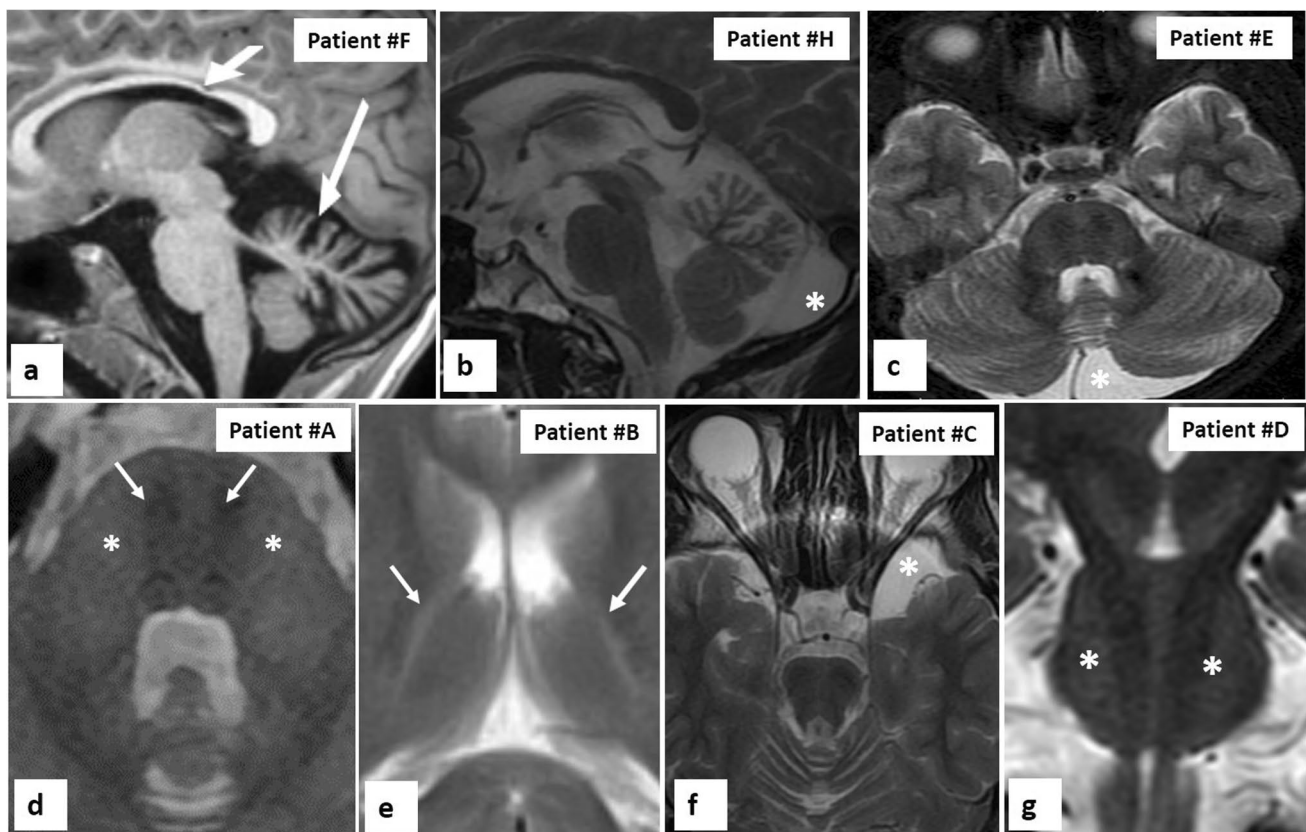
Significant MRI findings in ARSACS patients. a Thinning of the posterior mid-body of the corpus callosum (short thick arrow) as well as the superior cerebellar vermis atrophy (long thin arrow) in patient F (*SACS: c.3427C>T*). b Posterior fossa arachnoid cyst (asterisk) in patient H (*SACS: c.7504C>T*). c Asymmetry of the posterior fossa (asterisk) in patient E (*SACS: c.3281dupA*). d
